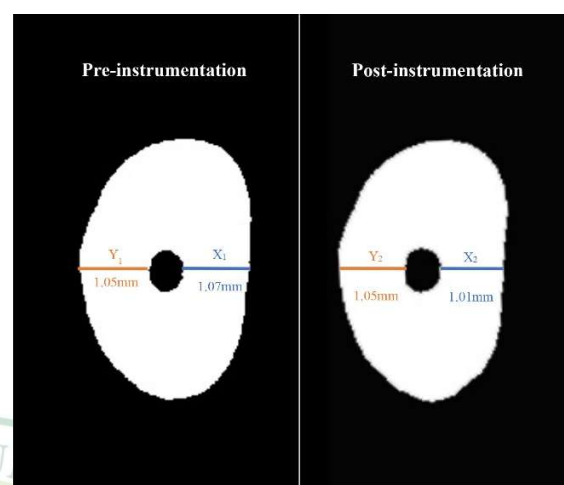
Microcomputed tomography reconstructions of the root canal cross-section before and after instrumentation. X1, X2 and Y1, Y2 represent root canal wall widths before and after canal preparation.
